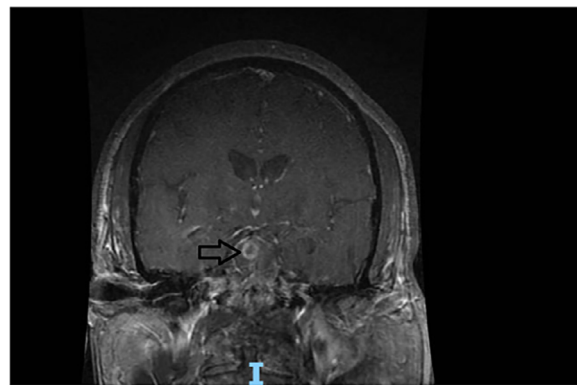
MRI of the brain with and without contrast coronal section.
